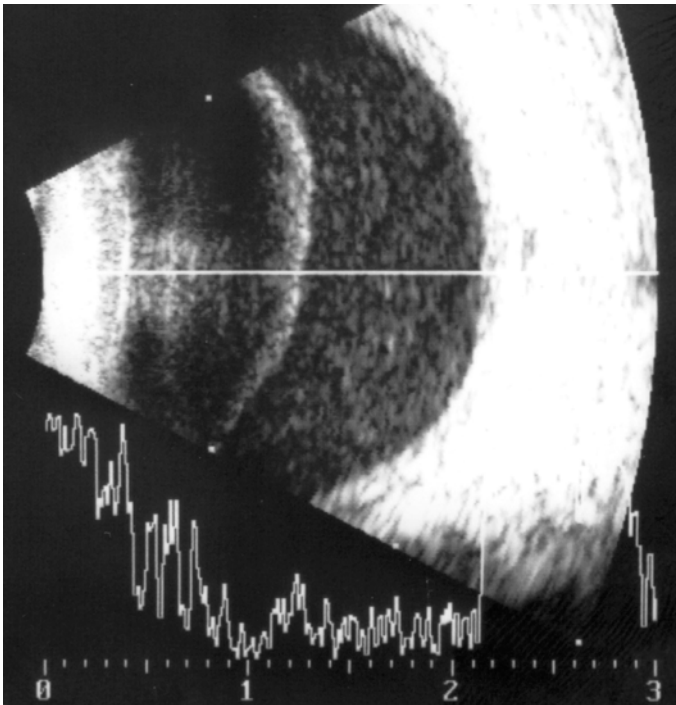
Ultrasound imaging of an eye with hazy vitreous due to endophthalmitis. The preoperative image suggests posterior vitreous detachment with subhyaloid infiltration. During surgery, however, a nondetached vitreous was found with a complete retinal detachment and a subretinal fluid rich in protein and cellular elements
